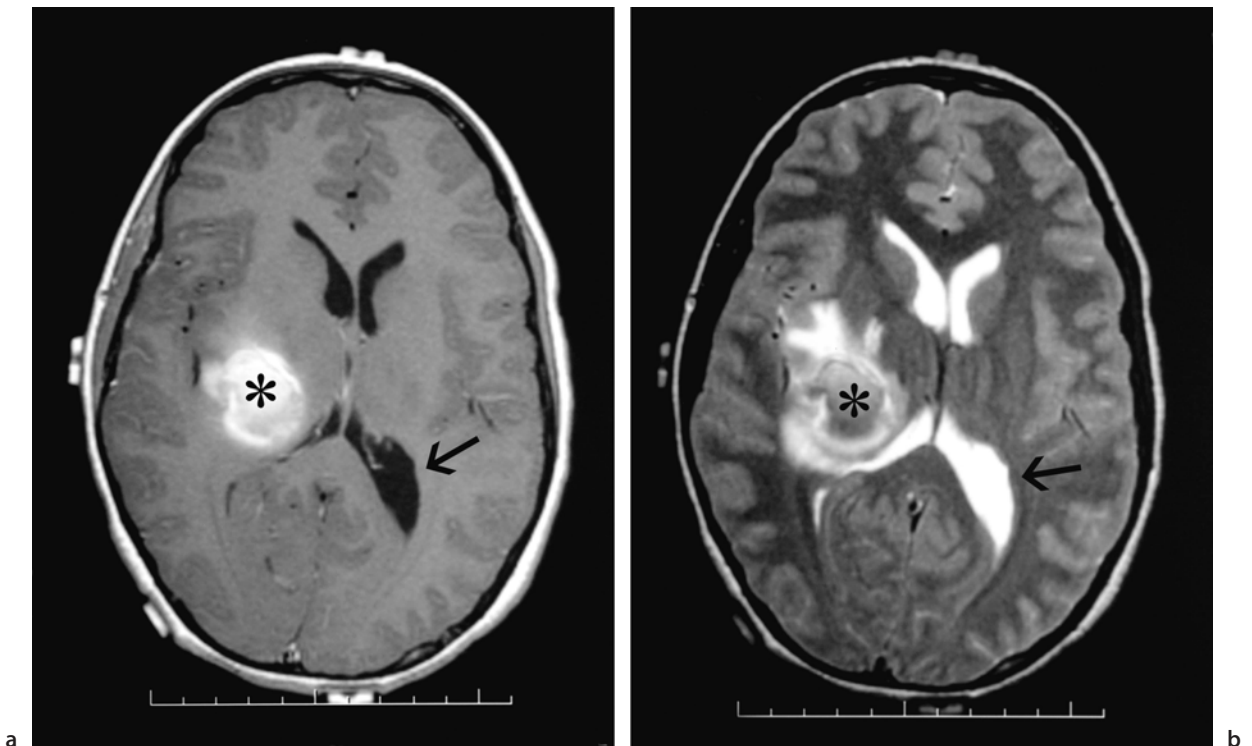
MR imaging of the brain
